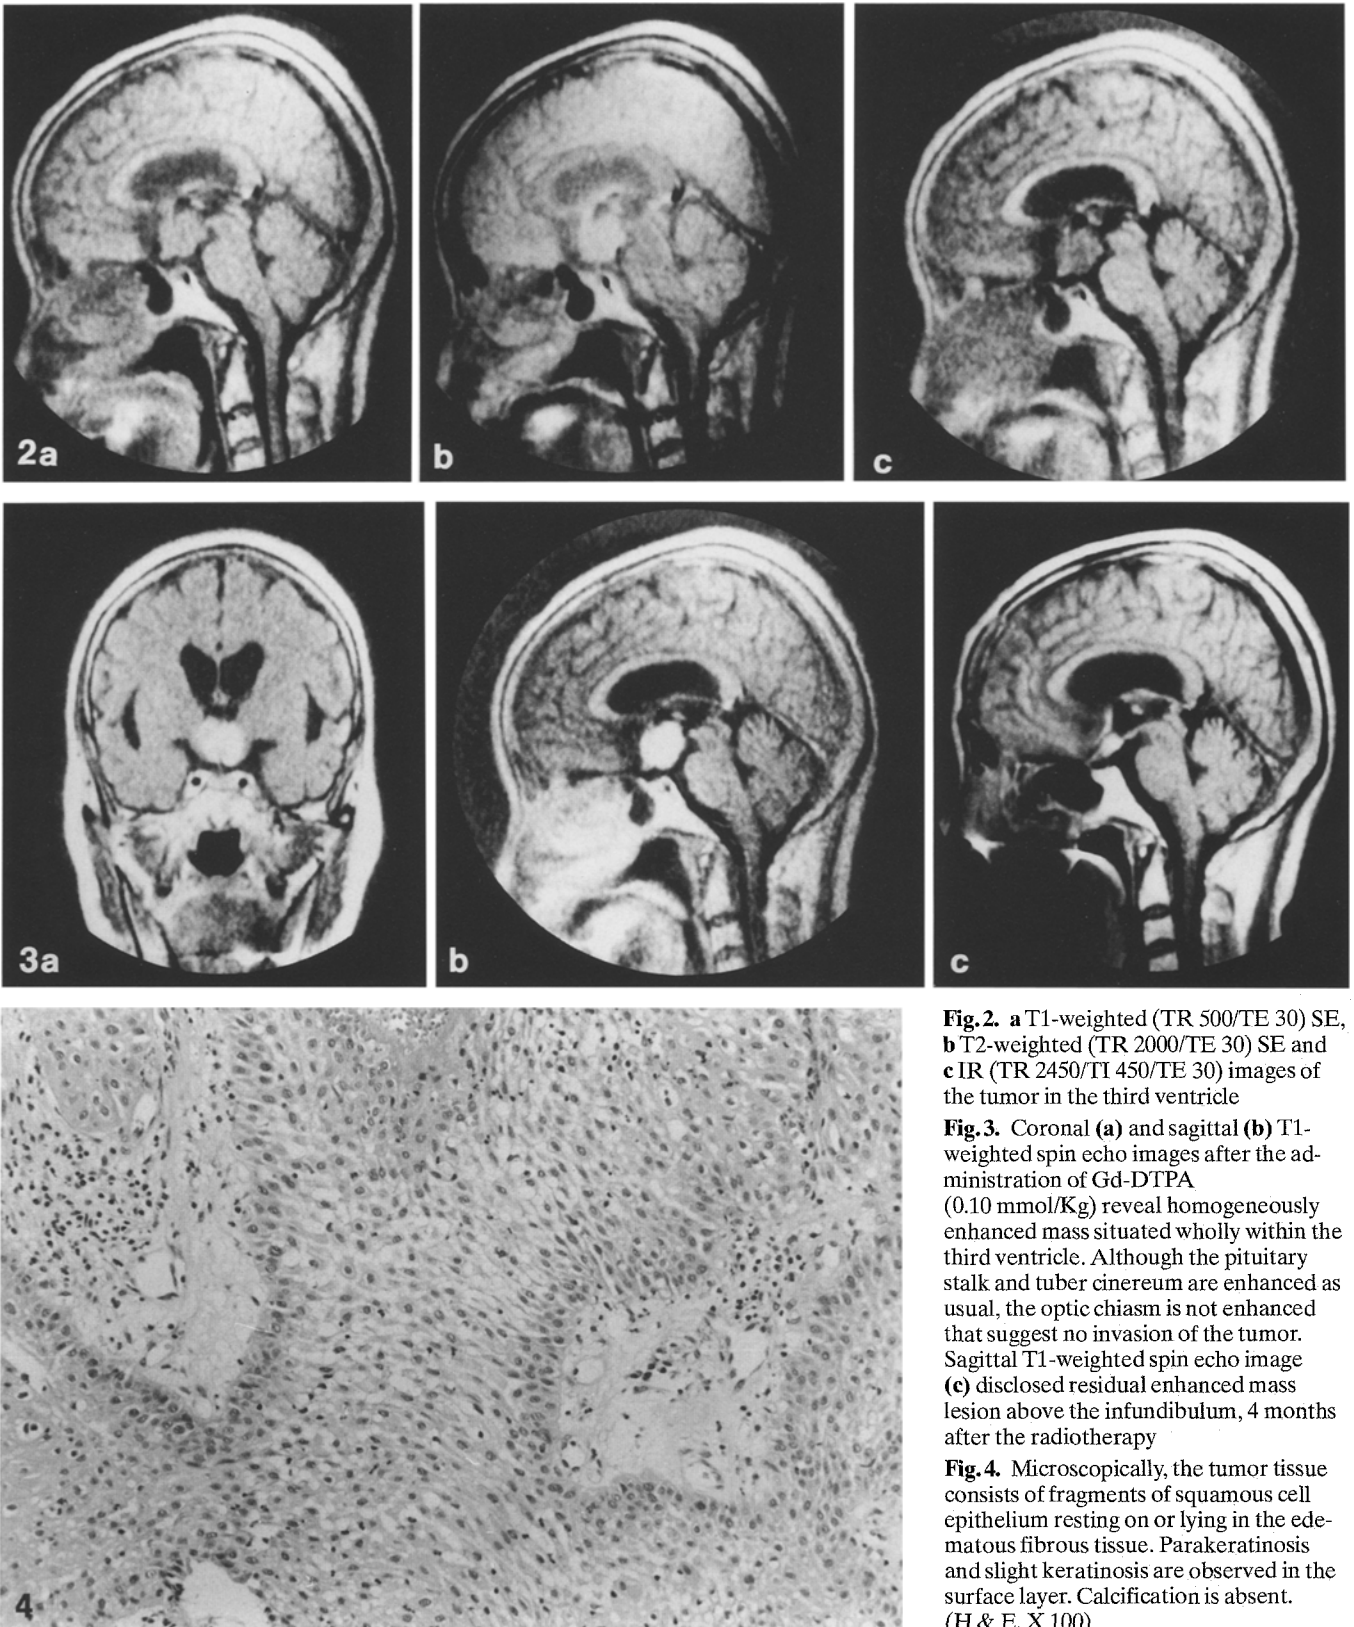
a T1-weighted (TR 500/TE 30) SE, b T2-weighted (TR 2000/TE 30) SE and c IR (TR 2450/TI 450/TE 30) images of the tumor in the third ventricle
